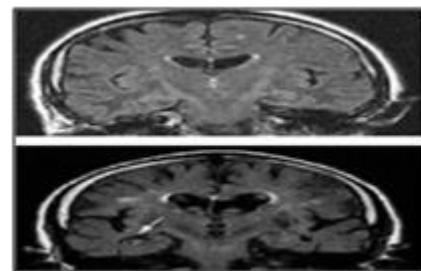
(b) MRI Scan Brain In Medial Temporal Atrophy
